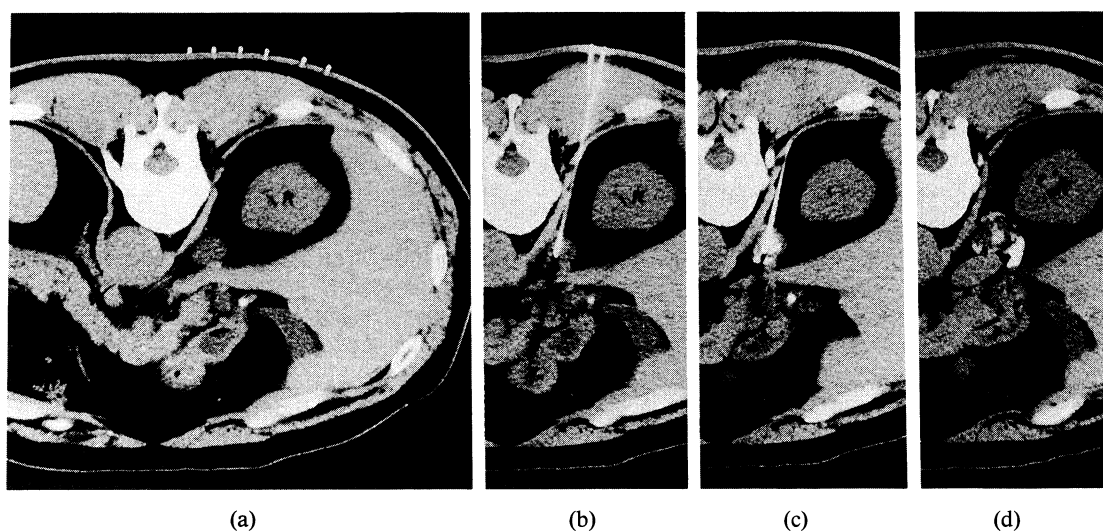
CT scan imaging during the PAI in Case 3. (a) The most appropriate insertion point was selected. (b) The needle was inserted and placed precisely within the tumor after repeated CT monitoring. (c) Acetic acid solution containing contrast medium was injected. (d) Total amount of injected 50% acetic acid solution was 1.5 ml.
